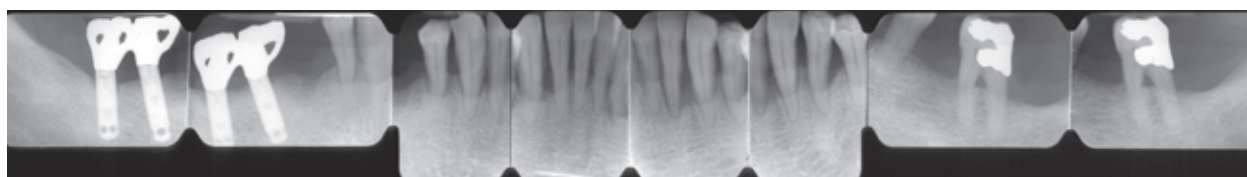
Pre-treatment radiographic examination of the mandibular arch.
